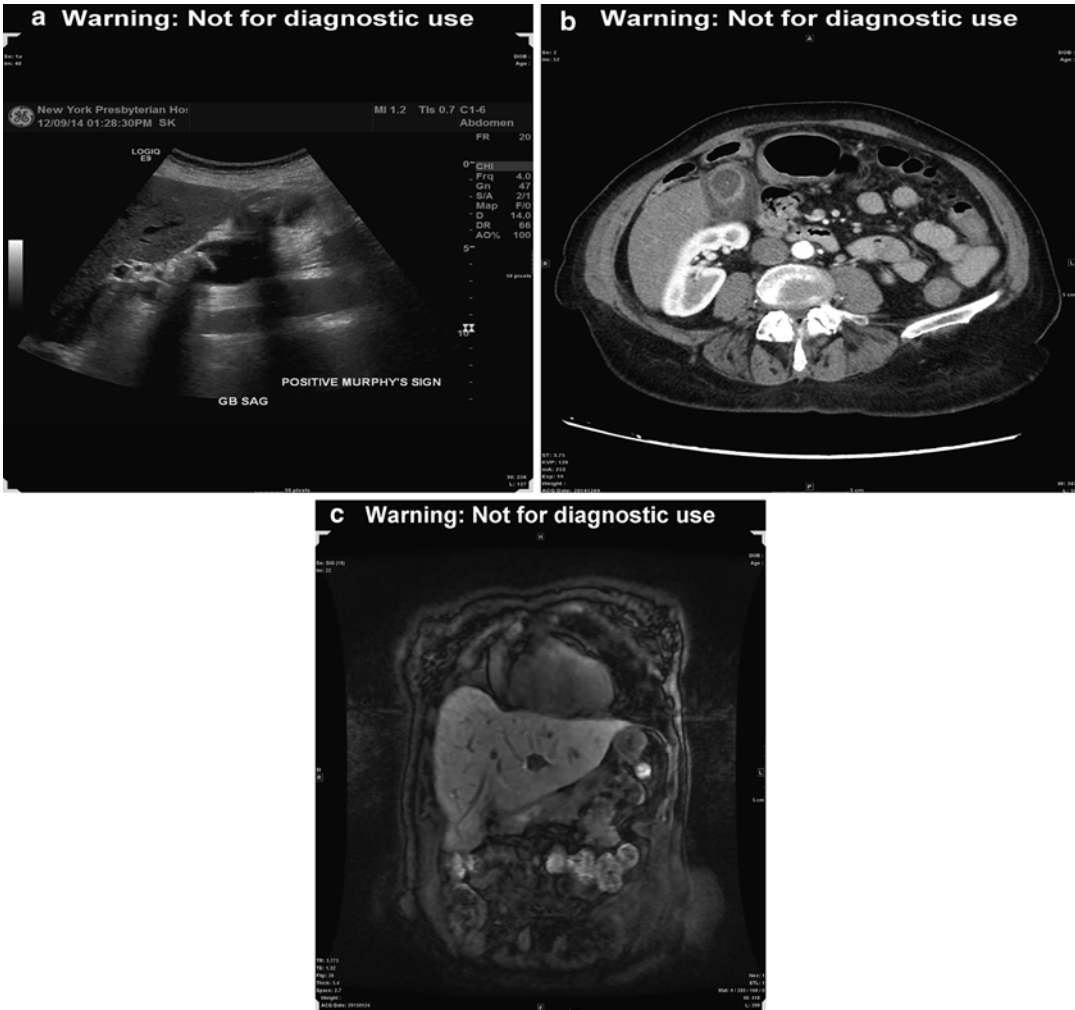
Seventy-three-year-old female presenting with right upper quadrant pain initially thought to be acute cholecystitis. Patient underwent laparoscopic cholecystectomy. Pathology revealed invasive adenocarcinoma of the gallbladder with high-grade dysplasia and invasion of perimuscular connective tissue (T2, Nx). (a) Preoperative right upper quadrant ultrasound image showing thickened gallbladder wall (9 mm), multiple gallstones, and sludge with normal intrahepatic ducts. Impression read as acute cholecystitis. (b) Preoperative axial CT-scan of abdomen showing 2.0 cm gallstone within the gallbladder neck. This is
